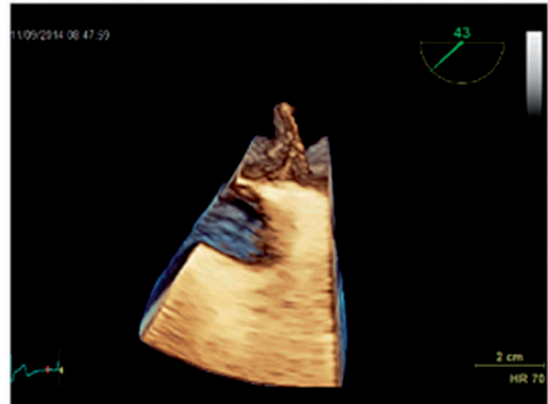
3D transesophageal echocardiography of a displaced atrial septal occluder (arrow).
